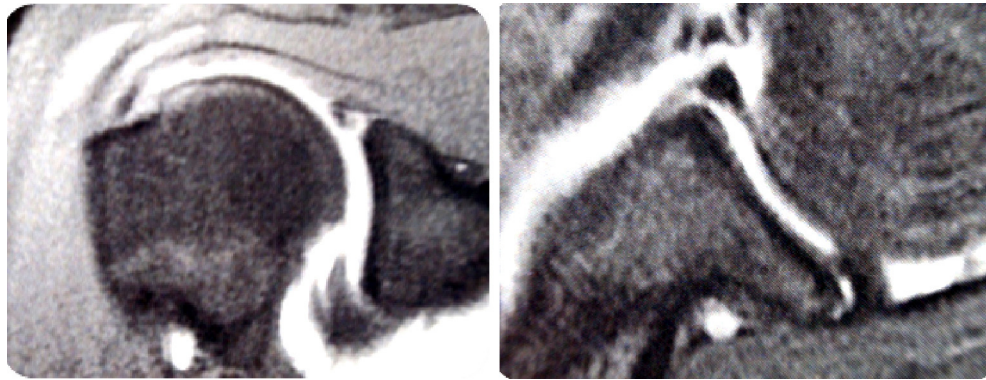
Arthrography MRI image of the right shoulder in the coronal and axial T2-weighted cuts showing the SLAP lesion (left) and the Bankart and posterior labral lesions (right).
